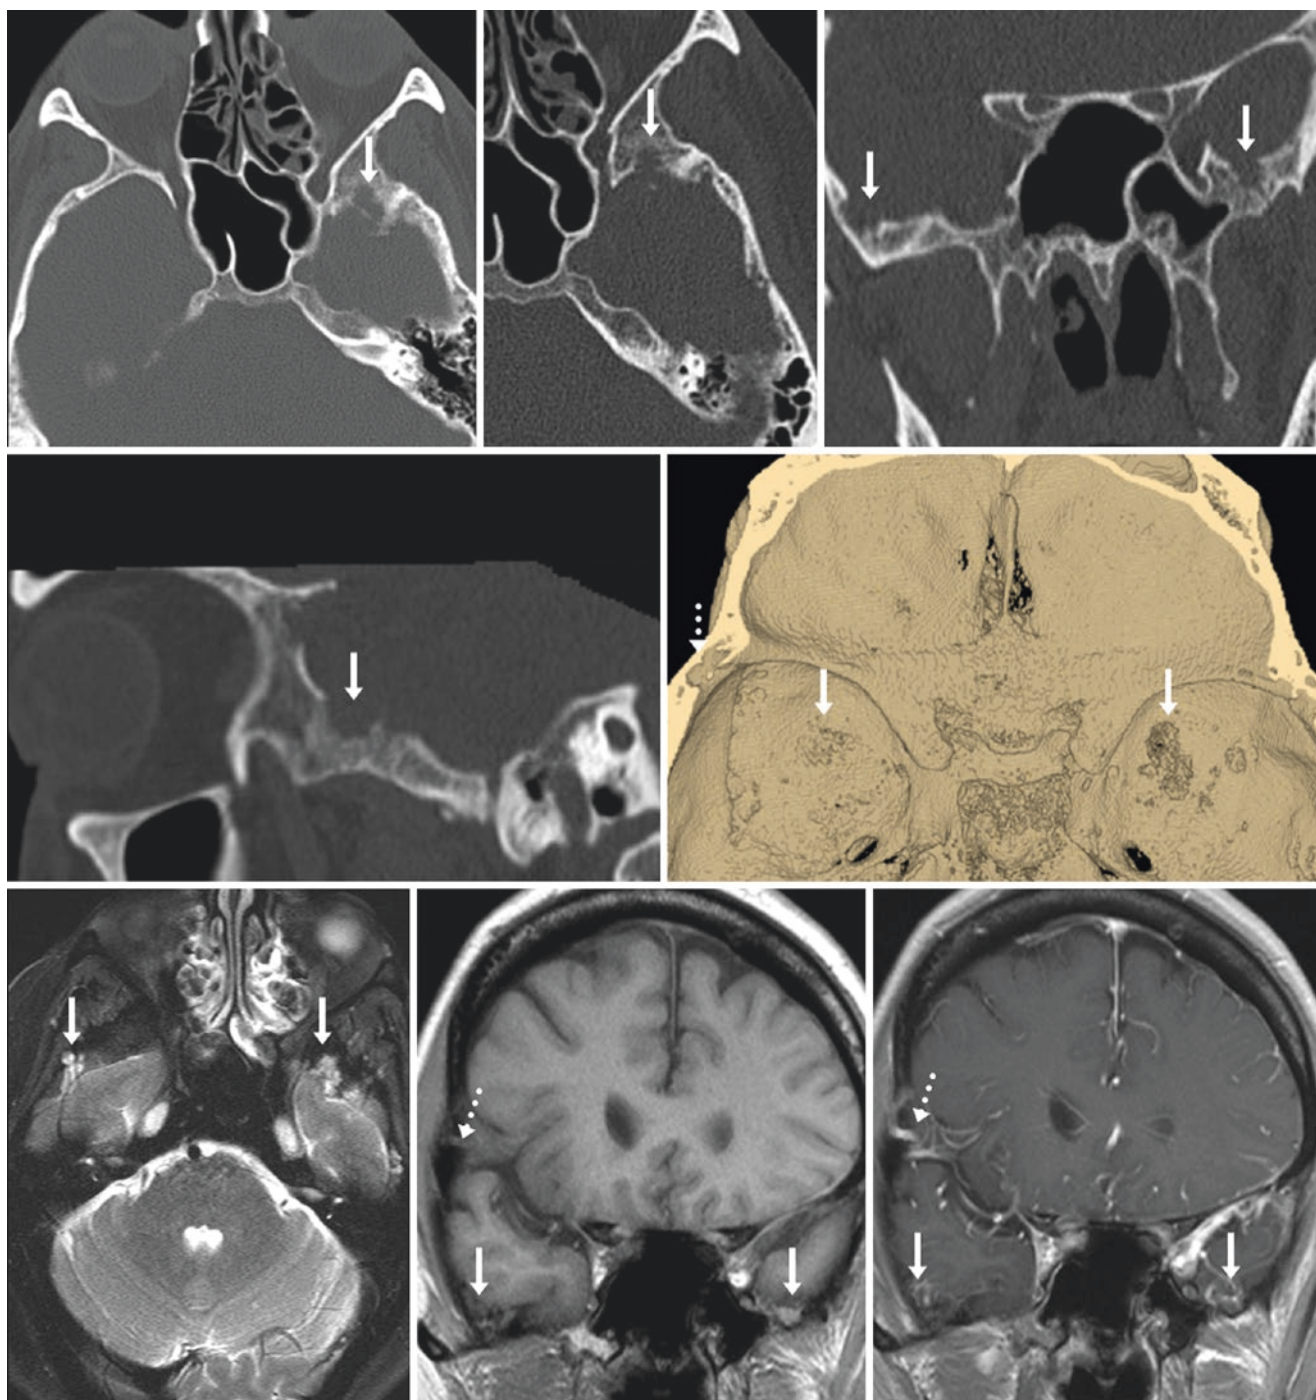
A 61 year old with a lytic lesion questioned in the left middle cranial fossa floor on axial NECT (*top left*). Axial and coronal reformats (*top middle and right*) showed defects within the left sphenoid greater wing, also noted on sagittal (*middle row, left*) and three-dimensional VR superior view (*middle row, right*). MRI confirmed
